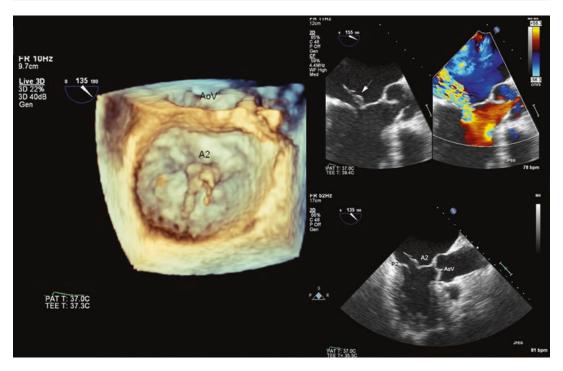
Anterior leaflet (A2). Left panel shows 3D left atrial view of a middle (A2) segment flail and multiple ruptured chordae. 2D imaging with colour Doppler is
